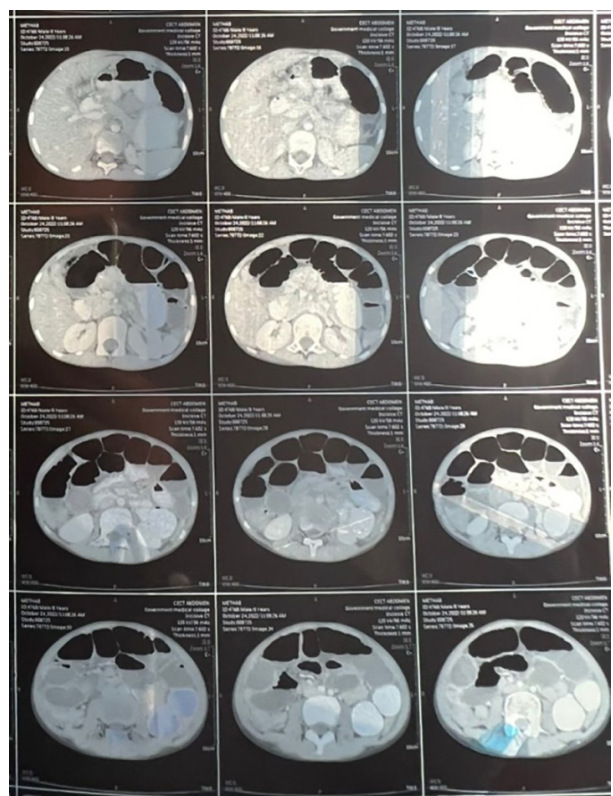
Contrast-enhanced computed tomography images of the patient indicate small bowel obstruction due to a terminal ileal amlookobezoar.
